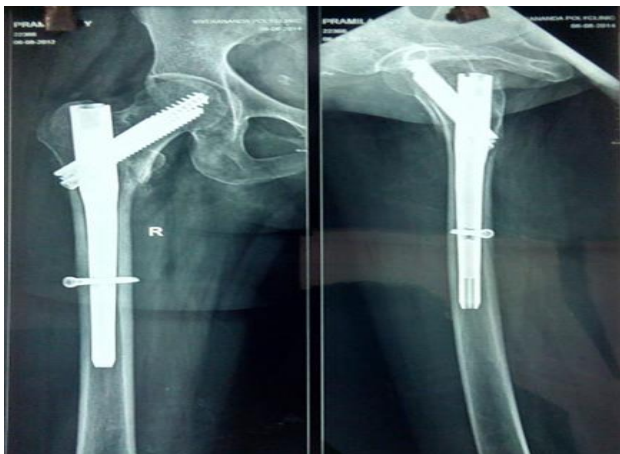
12 months post op X-ray showing union of the fracture.
